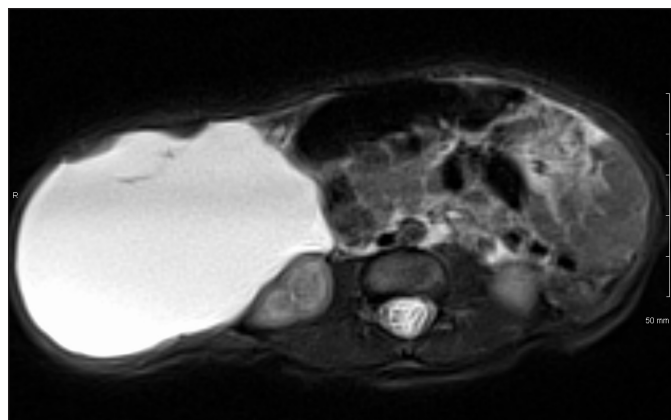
Postnatal MRI axial T2 image demonstrating a T2 hyperintense structure anterior to the right kidney. A small septation can be seen within the cyst anteriorly.
